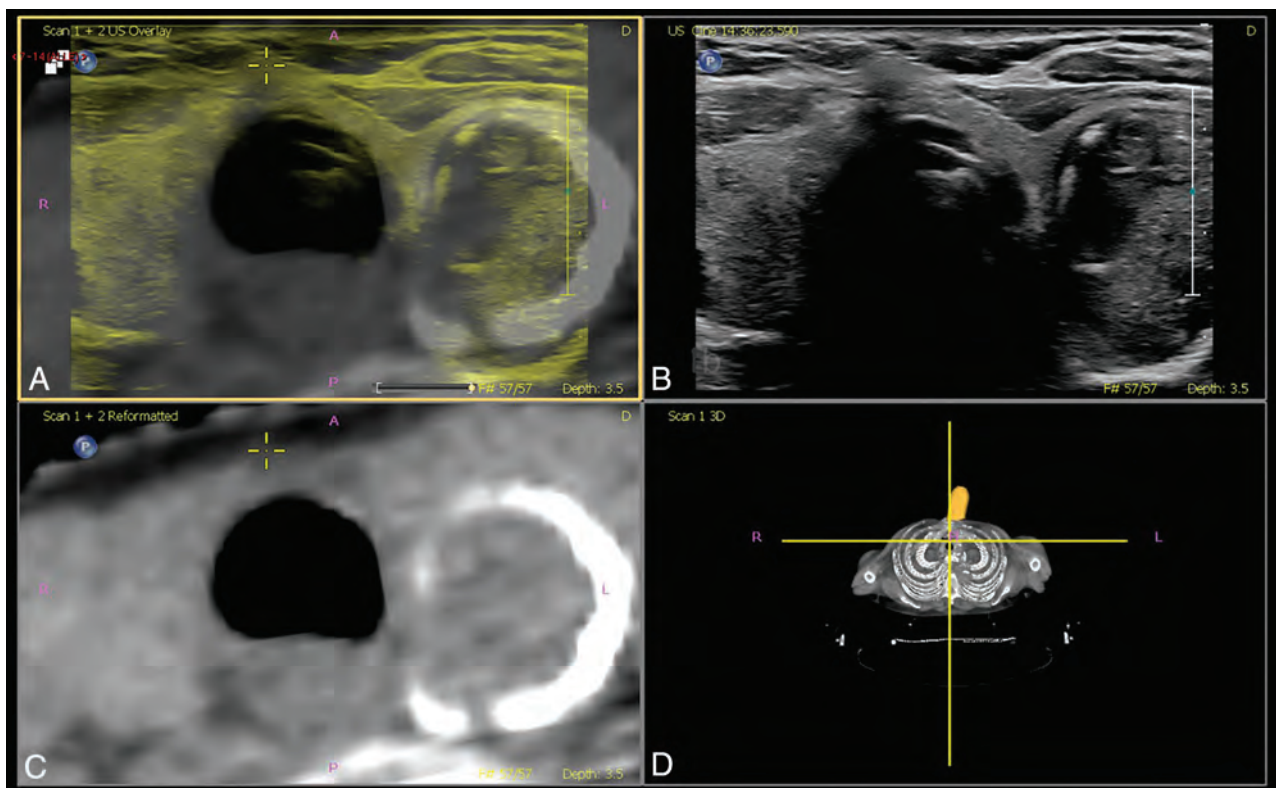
Matched plane fusion, manual correction. A, Overlay US (yellow) and CT (gray). B, US image. C, Reformatted CT image. D, Volume representation of CT image and probe location.
